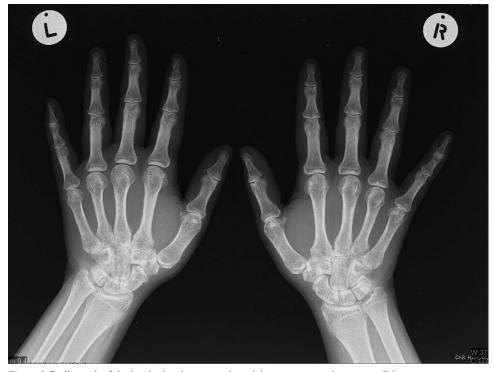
Radiograph of the hands showing no erosions, joint space narrowing, or pencil-in-cup appearance.
